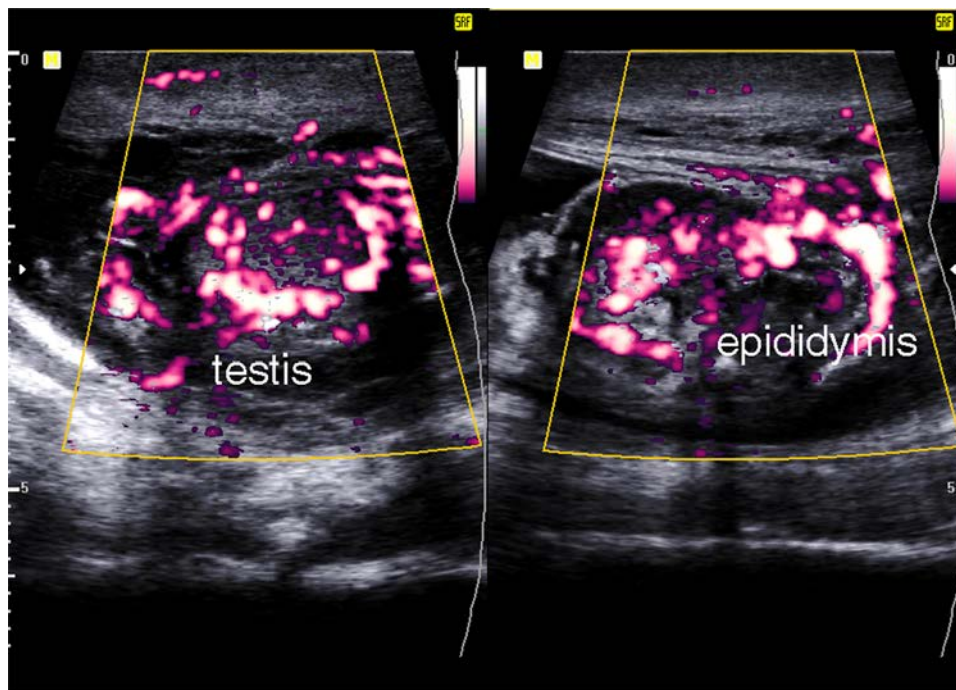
Color duplex sonography showing enlarged hypervascular epididymis and testis suggesting epididymo-orchitis.
